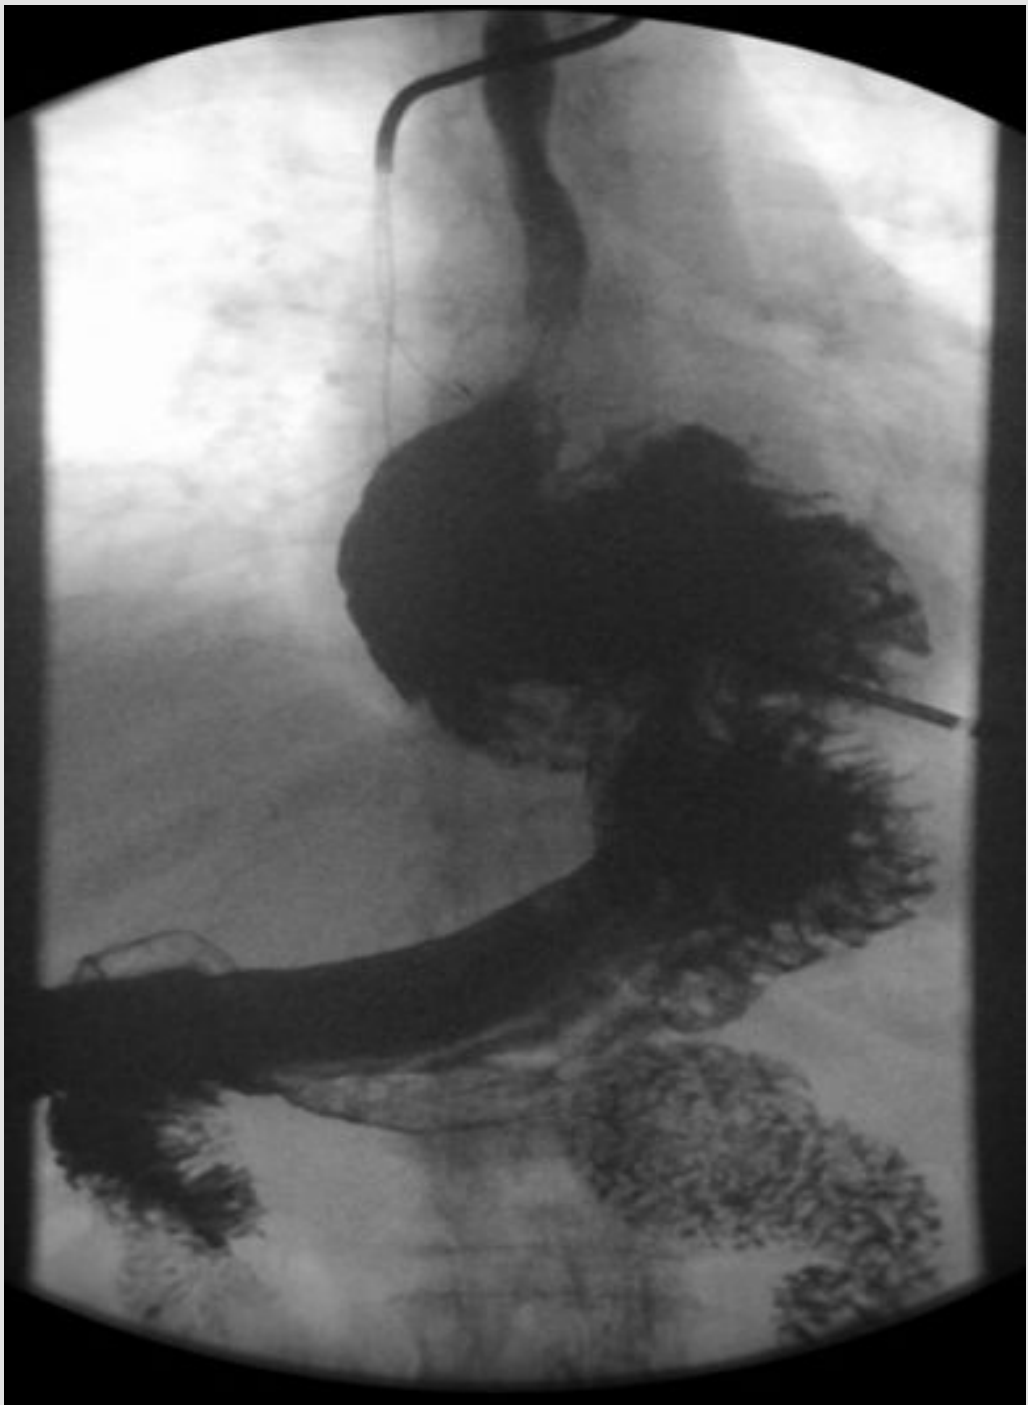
A (Left) esophagram showing a large hiatal hernia with most of the stomach above the diaphragm in the chest; B (right) computed tomography showing most of the stomach in the chest with compression on surrounding structures
